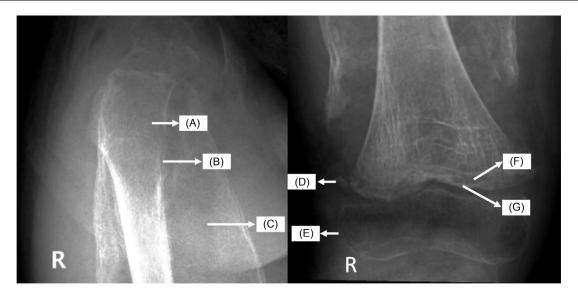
The right femur x-ray with its scorbutic features. The findings were consistent with the left femur. (A) Diffuse osteopenia; (B) Pencil-thin cortex; (C) Para epiphyseal subperiosteal haemorrhage; (D) "Pelkin fracture"; (E) "Wimberger ring sign"; (F) "Trümmerfeld zone"; (G) "White line of Frankel".
